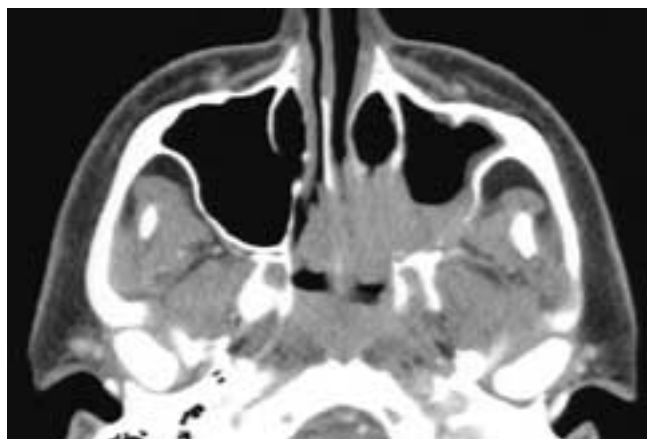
Axial CT scan shows a destructive mass in the left posterior nasal fossa that has destroyed portions of the medial and posterior left maxillary sinus walls. There is also some destruction of the left pterygoid process, and tumor extends into the left retromaxillary fat. This patient had a squamous cell carcinoma.
